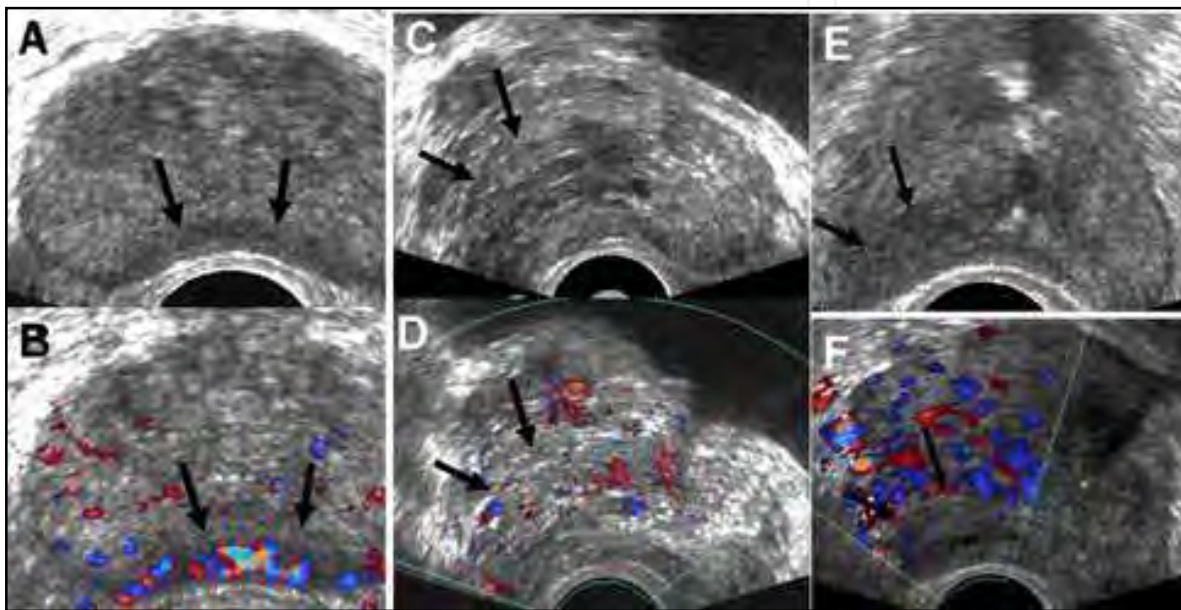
(A) TRUS shows hypoechoic areas proved to be cancer (arrows). (B) Color-Doppler shows the same area to be of high vascularity (arrows). (C) TRUS of another patient with prostate cancer appears as hypoechoic area (arrows). (D) The same area appears with normal vascularity in color Doppler. (E) TRUS of a third patient with hypoechoic lesion of prostate cancer appears as hypoechoic (arrows). (F) The same lesion appears of low vascularity in color Doppler
